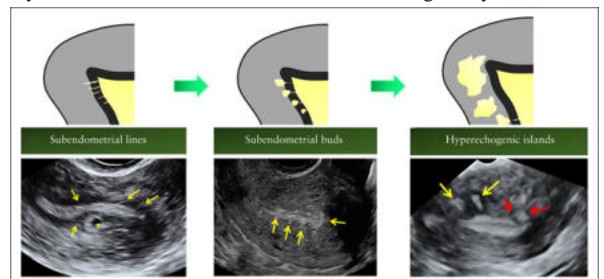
Transvaginal sonography showing features of adenomyosis
